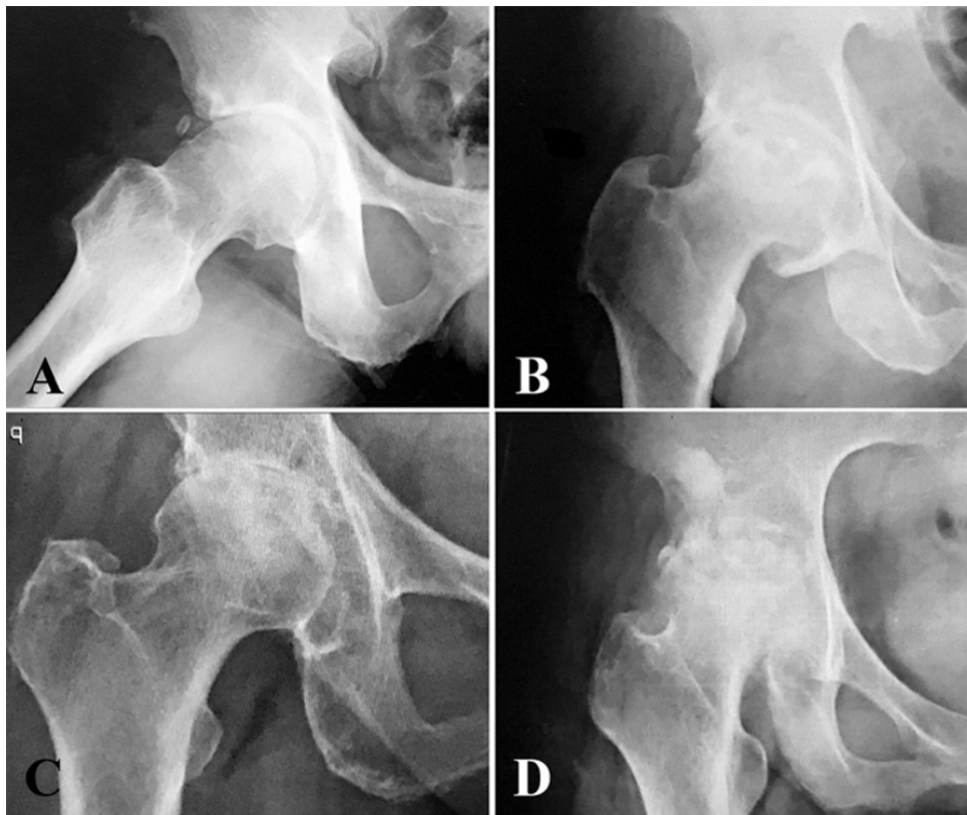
Examples of preoperative hip radiographs that were evaluated for cam morphology of the proximal femur and pincer morphology of the acetabulum: A) The lateral radiograph of the right hip showed an alpha angle >55 degrees, which was classified as “definite cam morphology”, B) The anteroposterior radiograph showed a lateral central-edge angle of more than 40 degrees, which was classified as “definite pincer morphology”, C) An osteoarthritis of the right hip without radiographic characteristics of cam or pincer morphology, which was classified as “no-cam morphology” and “no-pincer morphology”, D) A severe degree osteoarthritis of the right hip that was impossible to distinguish between cam or pincer morphology, and which was classified as “indeterminate morphology”.
